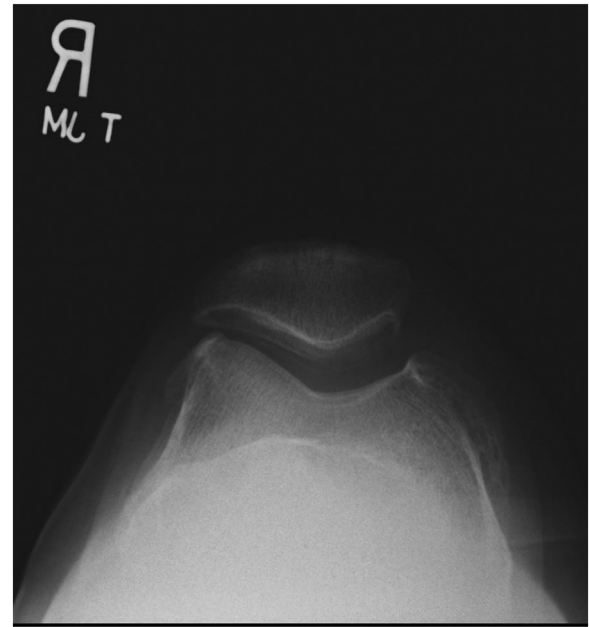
The Merchant radiograph of a right knee demonstrating an osteophyte on the lateral aspect of the trochlea.
